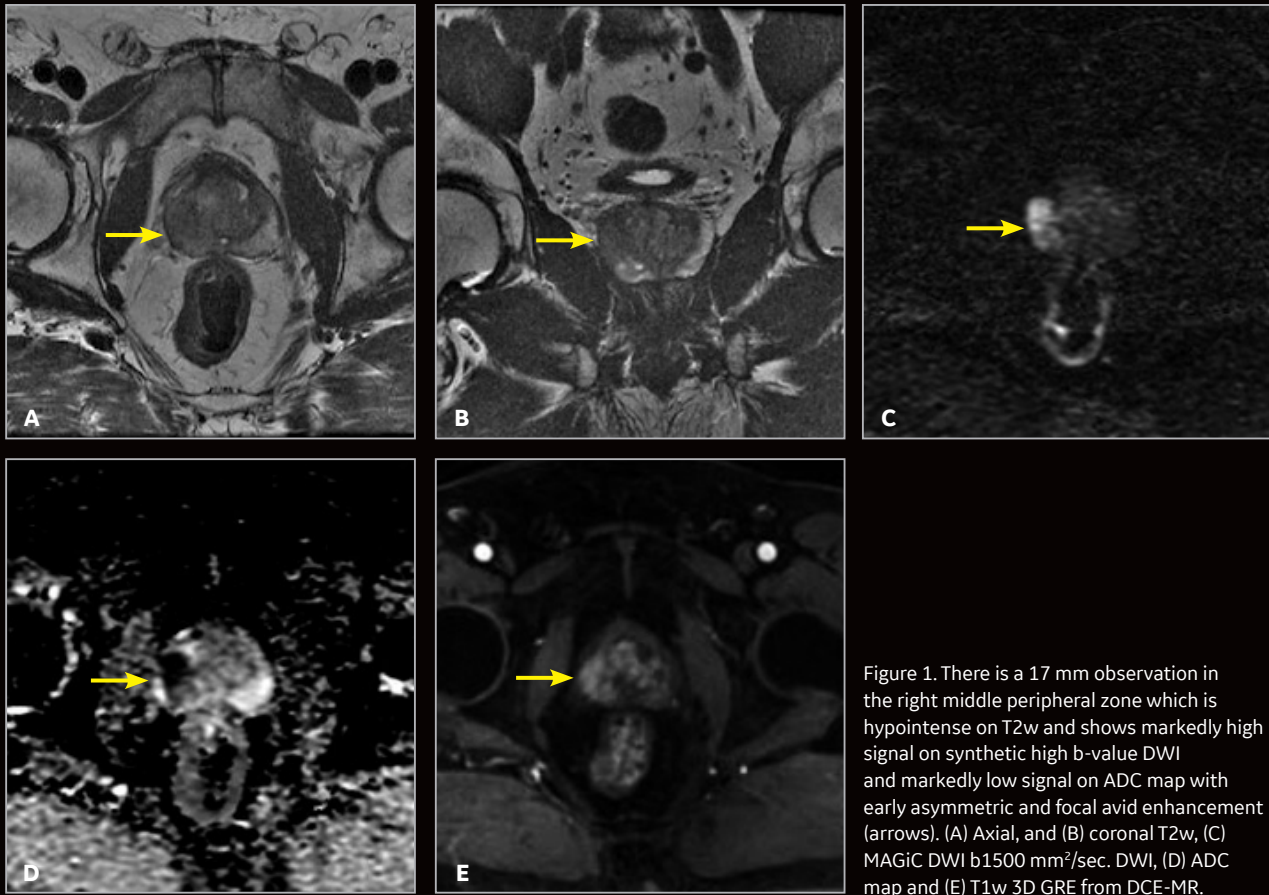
There is a 17 mm observation in the right middle peripheral zone which is hypointense on T2w and shows markedly high signal on synthetic high b-value DWI and markedly low signal on ADC map with early asymmetric and focal avid enhancement (arrows). (A) Axial, and (B) coronal T2w, (C) MAGiC DWI b1500 mm²/sec. DWI, (D) ADC map and (E) T1w 3D GRE from DCE-MR.
